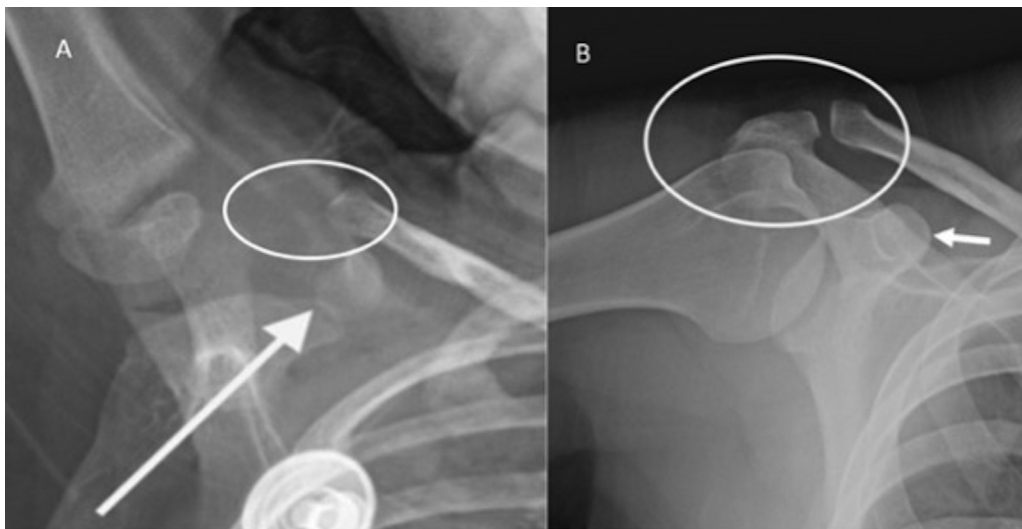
Anteroposterior view of shoulder radiographs showing (A) unfused coracoid process (white arrow) and nonossified acromion. Also, proximal humeral physis is completely unfused suggesting age less than 14 years. (B) Completely fused coracoid process (arrow), ossified acromion (white circle), and fused humeral physis indicating age above 17 years.
